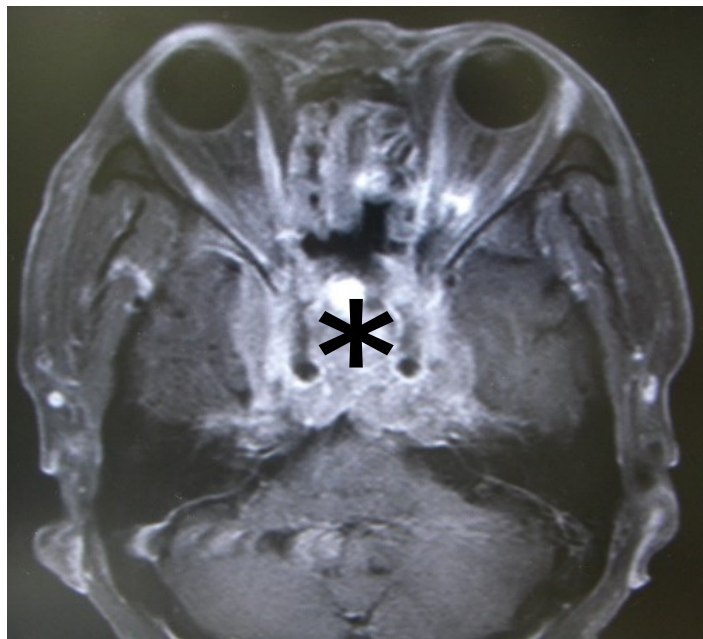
MRI demonstrated a metastatic tumor occupying the cavernous sinus and orbital apex. (asterisk)
